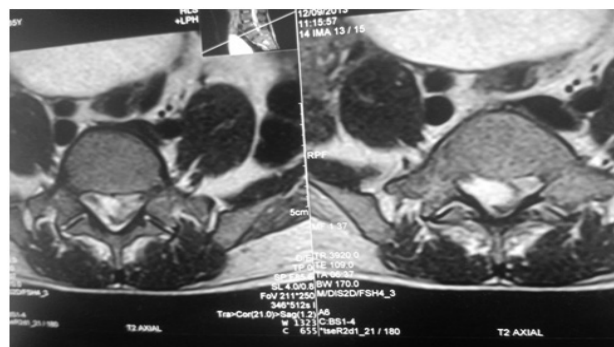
Axial MR image showing the epidural abscess compressing cauda equina.
